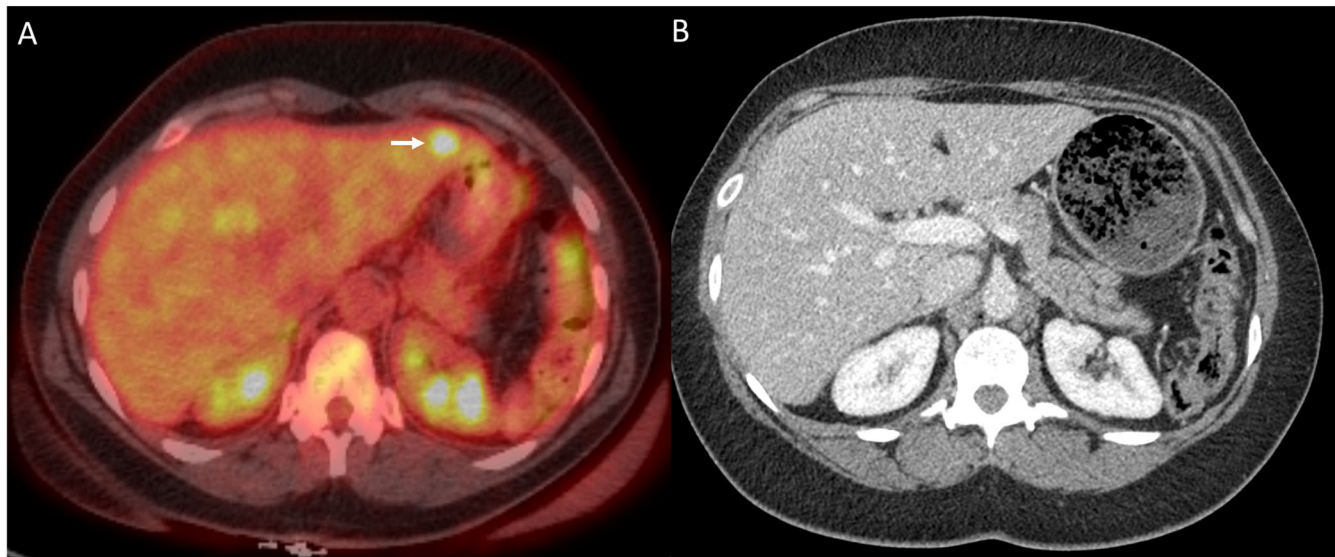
A 50-year-old male with a UrC-ADC. Axial fused ^{18}F -FDG-PET/CT (A) demonstrates an hepatic lesion (arrow), SUV_{max} 9.0, occult on prior CECT (B). The hepatic lesion was subsequently biopsied under ultrasound-guidance and proven to be a metastasis.
